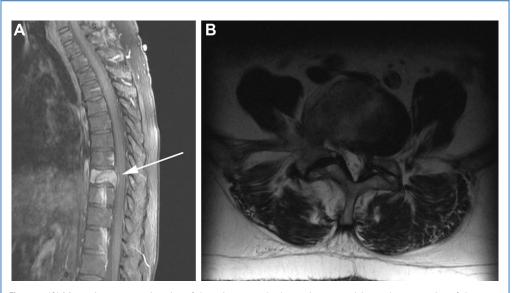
(A) Magnetic resonance imaging of thoracic spine reveals a 3-cm lesion (*arrow*) in the T9 vertebral
